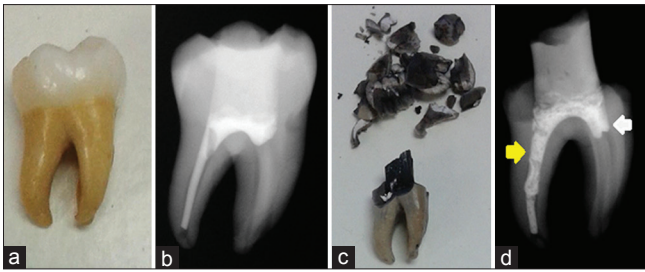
a) A sample of an extracted mandibular first molar tooth. b) An access cavity was prepared, and the distal root was obturated using a single cone (gutta percha size 30 – 0.04 taper). The mesial root was left untreated, and the access cavity was restored. The sample was introduced in a furnace at 500°C for 20 mins. c) After cooling, the sample showed fracture of the crown into pieces, and the colour turned black. d) A periapical radiograph showing the effect of heat on the gutta percha in which the spaces left from inadequate obturation in the distal root were filled by the molten gutta percha leaving some voids (yellow arrow). The molten gutta percha was able to go few millimeters into the mesial orifices (white arrow)
